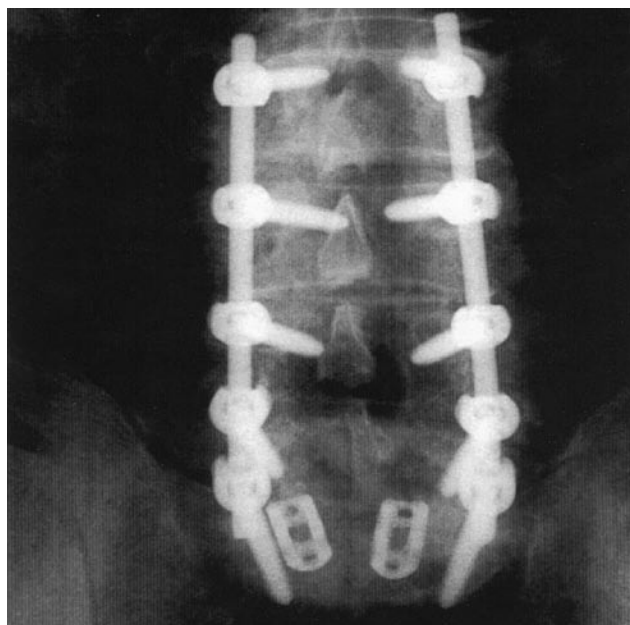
Anteroposterior x-ray obtained 6 months after surgery shows Actifuse in the lateral gutter of this multilevel posterolateral instrumented lumbar fusion. The granular nature of Actifuse is no longer evident, and the synthetic bone graft is integrated into the fusion mass. Of particular note, the margins of the visible fusion mass are smoothly contoured, which may correspond to formation of a pseudocortex.
